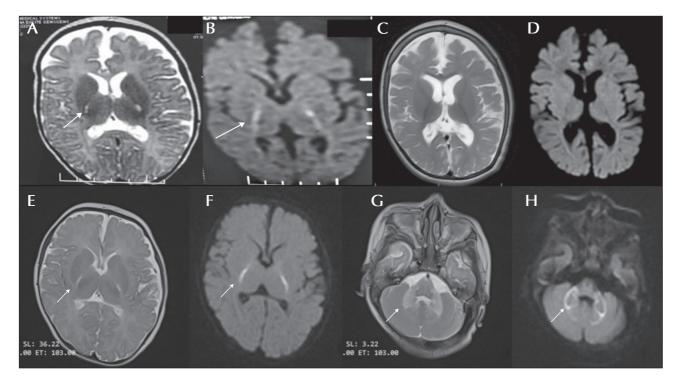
(A-D) Patient 1: T2 axial and diffusion-weighted images showing T2 hyperintensity in the posterior limb of the internal capsule (arrow [A]) with diffusion-restriction (arrow [B]) of the same region. At 18 months of age, brain MRI in the same patient shows diffuse cortical atrophy on T2 axial image (C) and resolution of diffusion-restriction in the previously involved area (D). C-H) Patient 2: T2 axial and diffusion-weighted images showing T2 hyperintensity in the posterior limb of the internal capsule (E) and dentate nucleus (G) with diffusion-restriction in the same areas (F, H).
